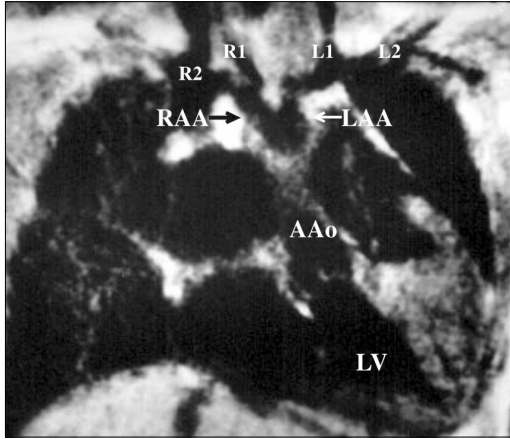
Magnetic resonance imaging in a 6.5-year-old boy visualized that the right and the left brachiocephalic arteries arose separately from the ipsilateral right aortic arch (RAA) and left aortic arch (LAA). The R1, R2, L1, and L2 denote the right common carotid artery (1st branch of the right aortic arch), right subclavian artery (2nd branch of the right aortic arch), left common carotid artery (1st branch of the left aortic arch), and left subclavian artery (2nd branch of the left aortic arch), respectively.
